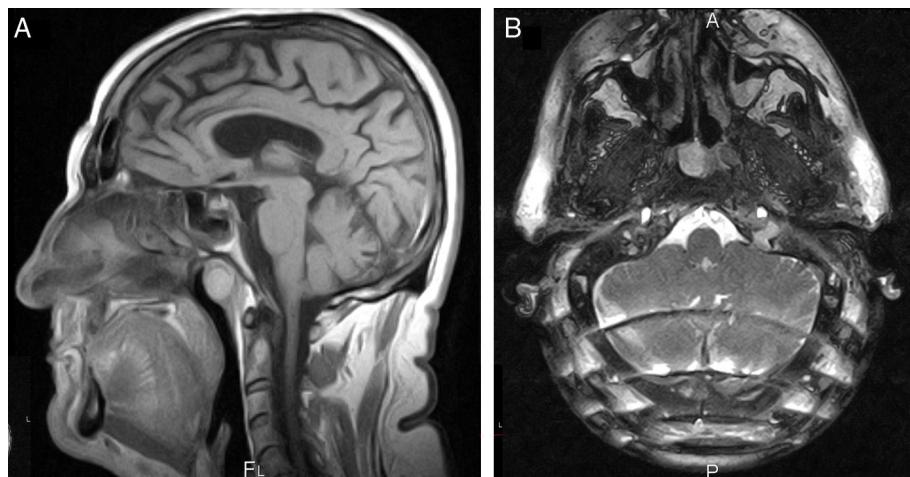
(A) MRI sagittal slice: rounded nasopharyngeal tumour is observed, of cyst like appearance. There are no bone erosions nor sign of changes in surrounding tissues. (B) Nasopharyngeal tumour in axial slice.
